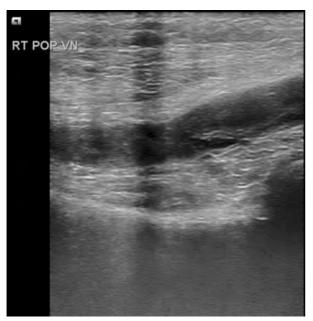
Venous Doppler: Right Popliteal vein thrombus
